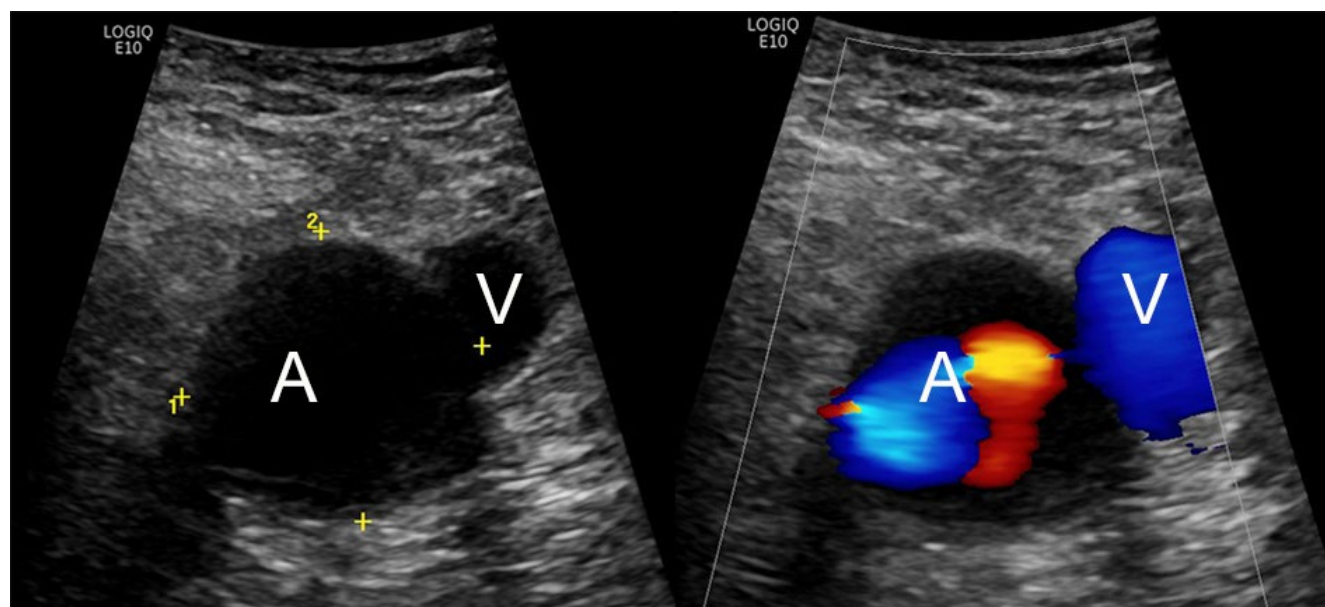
69-year-old male with popliteal artery aneurysm. Transverse grayscale and color Doppler US images show enlarged popliteal artery (A) adjacent to the normal vein (V) with internal turbulent flow
